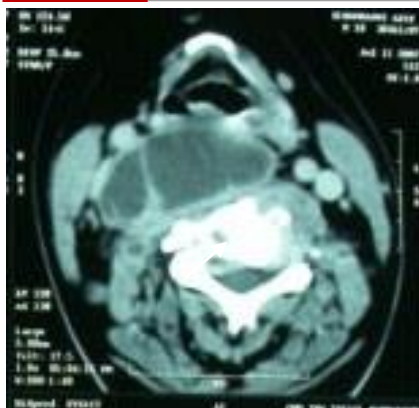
Retropharyngeal tuberculosis abscess; Cervical CT, The arrow showing an important retropharyngeal collection, reaching the cervical spine with spondylodiscitis
